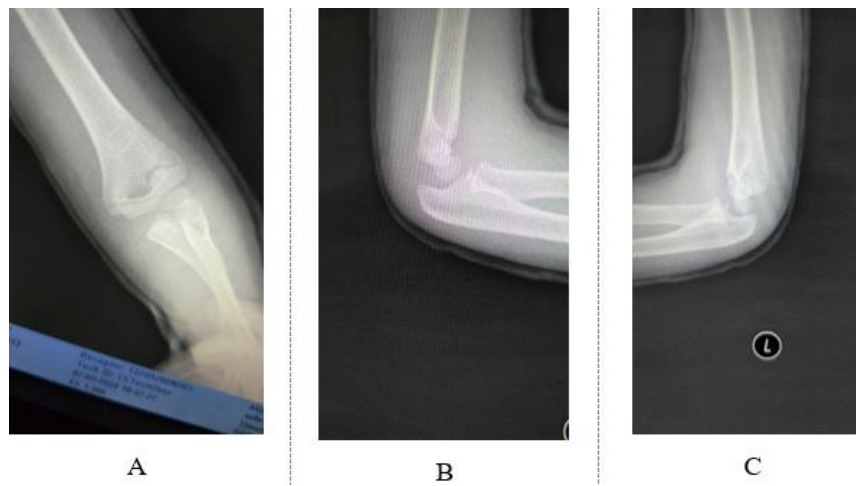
One-Week Follow-Up Radiographs Confirming Maintenance of Fracture Reduction and Alignment in High Above-Elbow Cast
